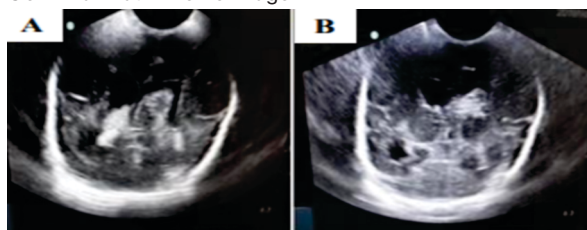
Coronal sections of the neurosonogram at different levels depict hyperechoic content within bilateral lateral ventricles causing its dilatation
